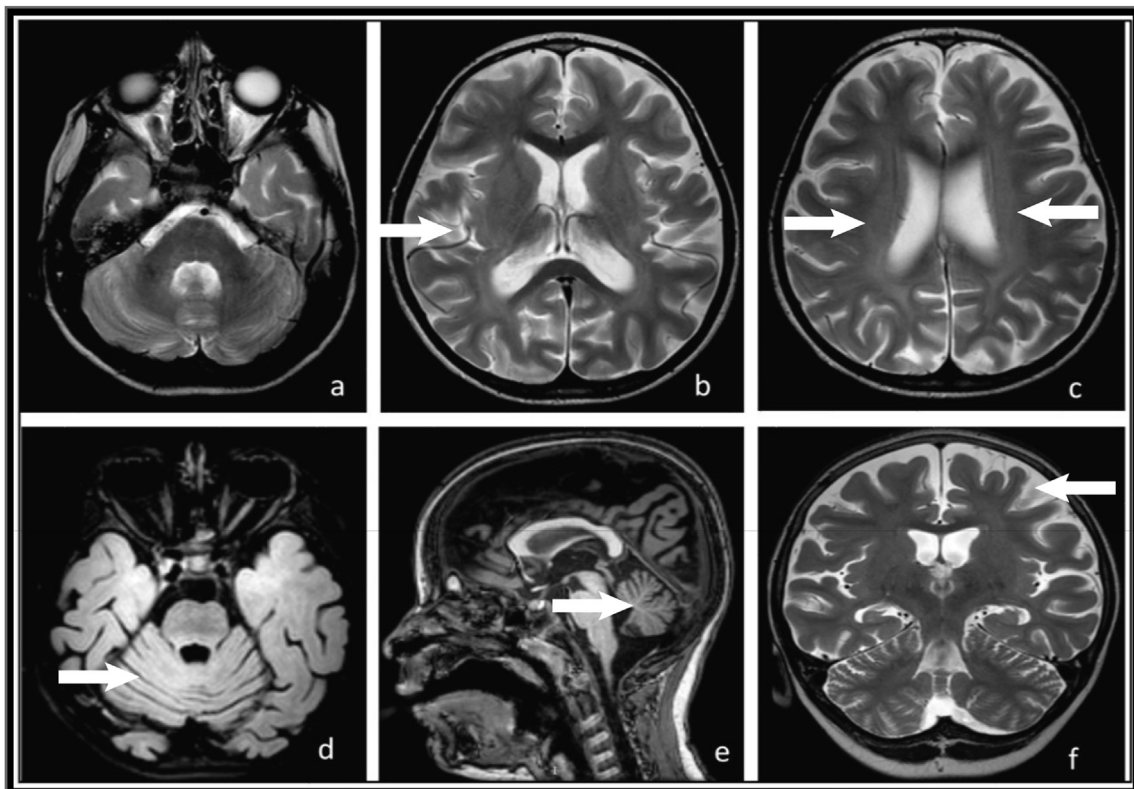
Patient 5 – T2-weighted axial sections (a, b, c), axial FLAIR section (d), T1-weighted sagittal section (e) and T2-weighted coronal section (f) from an MRI scan taken 2 years after the onset of symptoms. This scan clearly shows mild to moderate cerebral (b, f) and cerebellar (d, e) atrophy and linear hyperintensity of central white matter (c), demonstrating rapid disease progression over 2 years.
